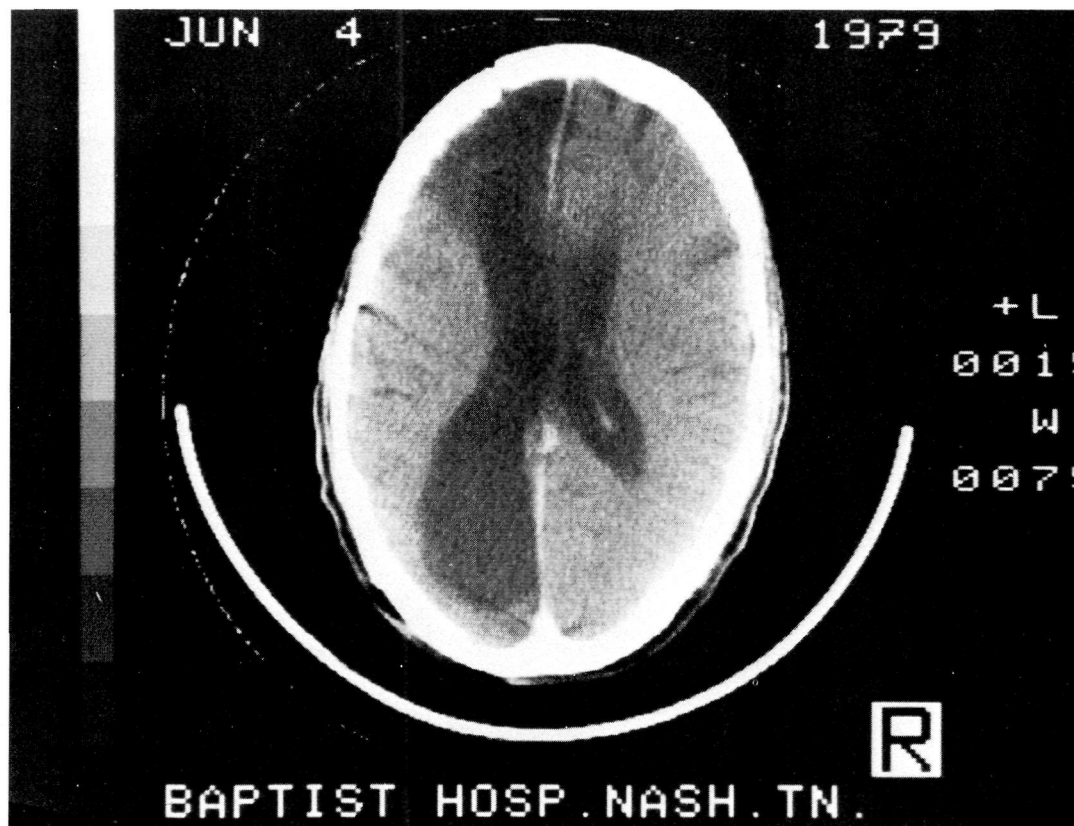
CT Scan, showing a higher tomographic cut.
